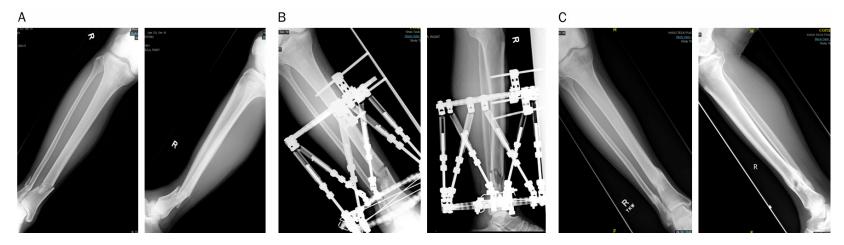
A 52-year-old male involved in a road traffic accident, sustaining a comminuted distal tibia fracture with poor skin condition overlying fracture site. A. Preoperative anteroposterior and lateral radiographs. B. Immediate postoperative anteroposterior and lateral radiograph after multiplanar external fixation. C. 1-year postoperative anteroposterior and lateral radiographs showing bony union and minimal angulation.
